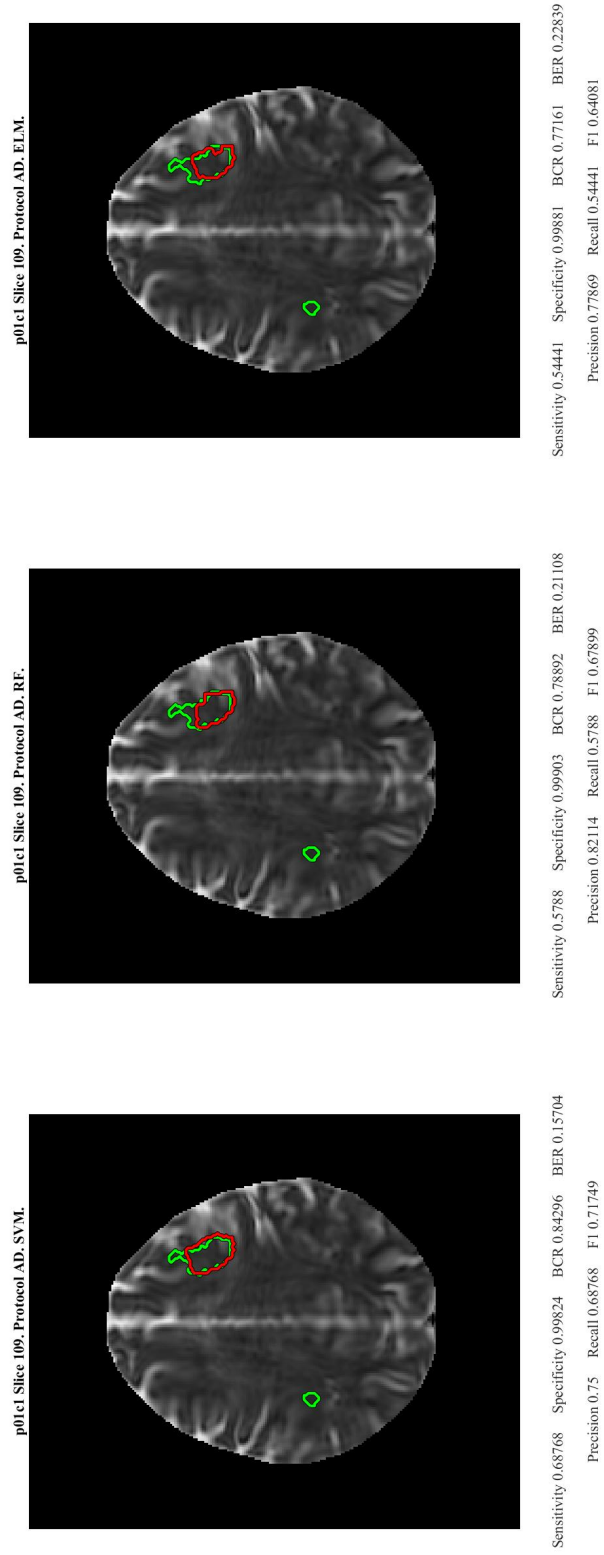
(a) Segmentations using all machine learning classifiers trained on Multimodal MRI data and features selected using LASSO feature selection for MS identification of dataset p01c1 AD sequence on slice 109.
